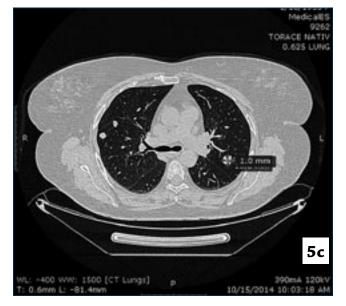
$a \rightarrow$ 5e. Thoracic CT images 2014 – multiple bilateral nodules, some calcified
